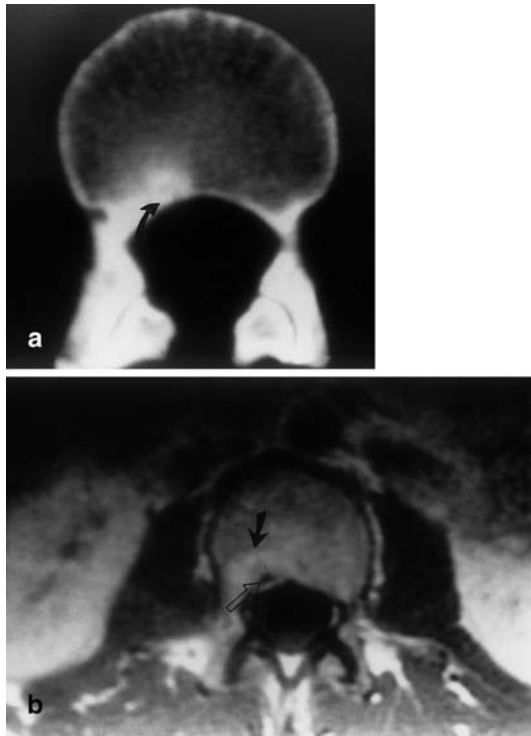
Osteoid osteoma of L3 vertebra. a Computed tomography shows a hypodense area surrounded by sclerosis at the posterior cortical surface of the vertebral body. Note the calcified nidus (*arrow*). b Axial post-contrast T1-weighted images shows intense enhancement of the lesion (*arrow*) with central low-signal focus corresponding to the calcified nidus (*open arrow*)
